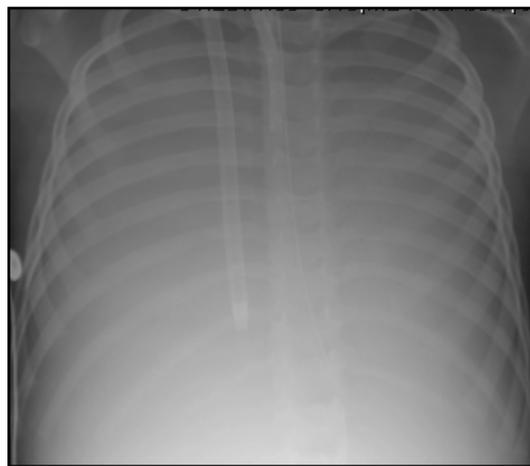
Chest X-Ray after initiation of extracorporeal membrane oxygenation
